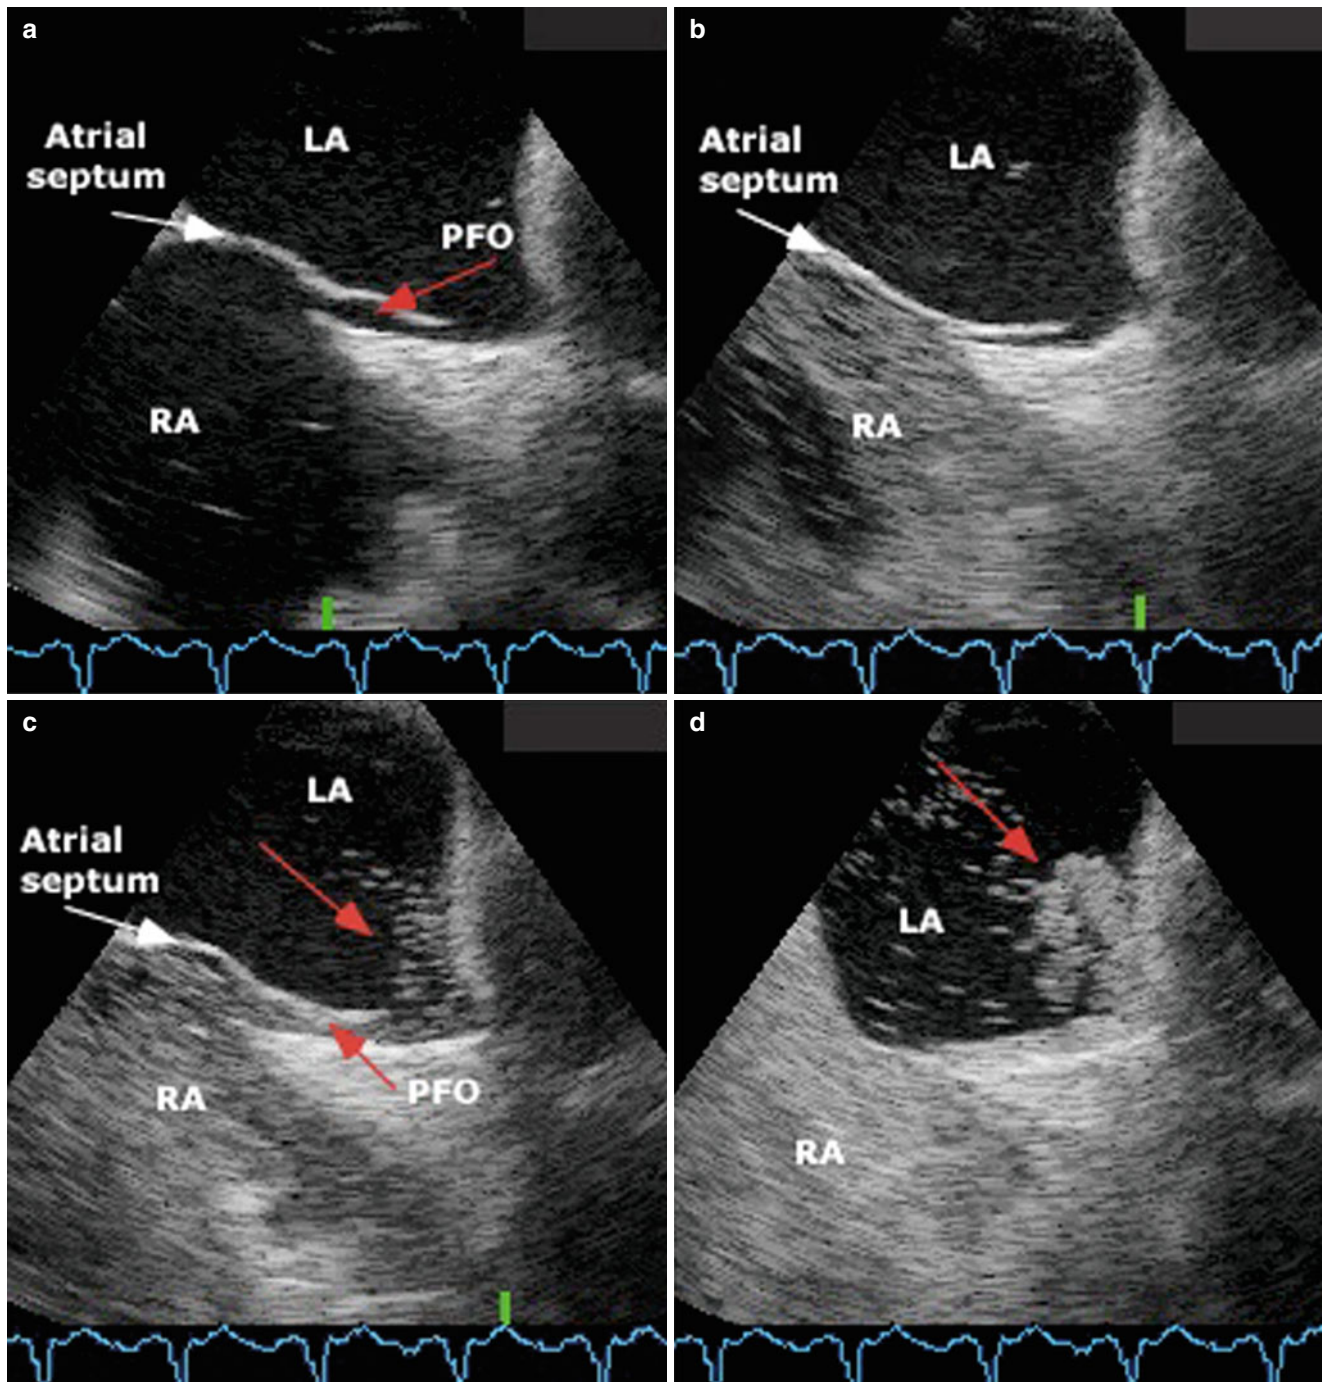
Transesophageal echocardiography with contrast of a patent foramen ovale. The sequence of images shows the right and left atria during diastole (panel a); a flap of the atrial septum is seen covering the foramen ovale. There is opacification of the right atrium immediately after injection of agitated saline (panel b). Panel c shows the contrast
